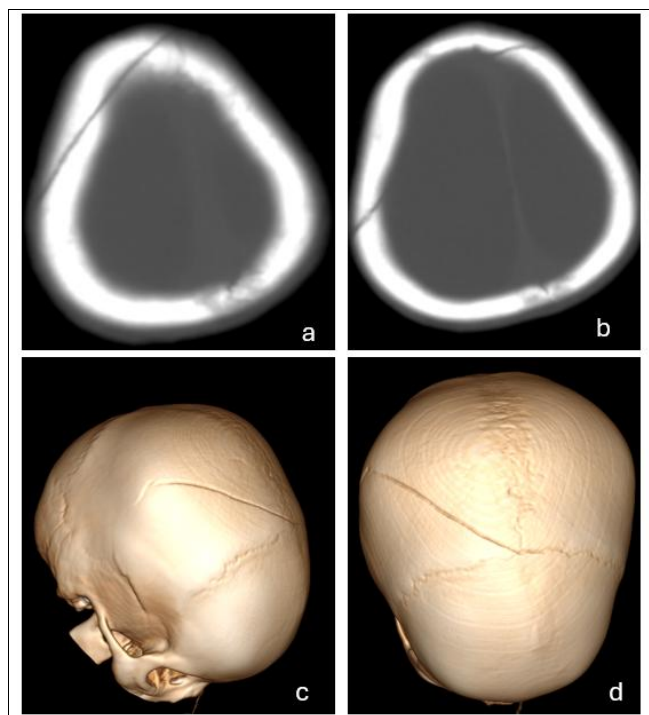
Axial non-contrast CT images in the bone window (a, b) and three-dimensional volume-rendered CT reconstructions (c, d) demonstrate a linear, non-depressed fracture involving the right parietal bone with extension into the squamous part of the right temporal bone and coronal suture
